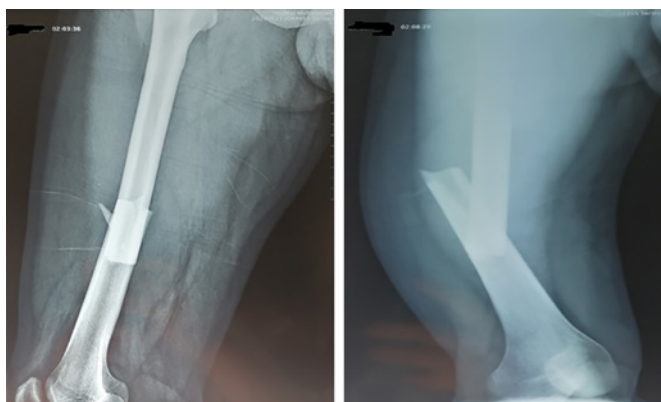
Standard X-ray imaging of the right thigh in antero-posterior (left) and lateral (right) views showing a displaced transverse fracture of the right femoral shaft.
